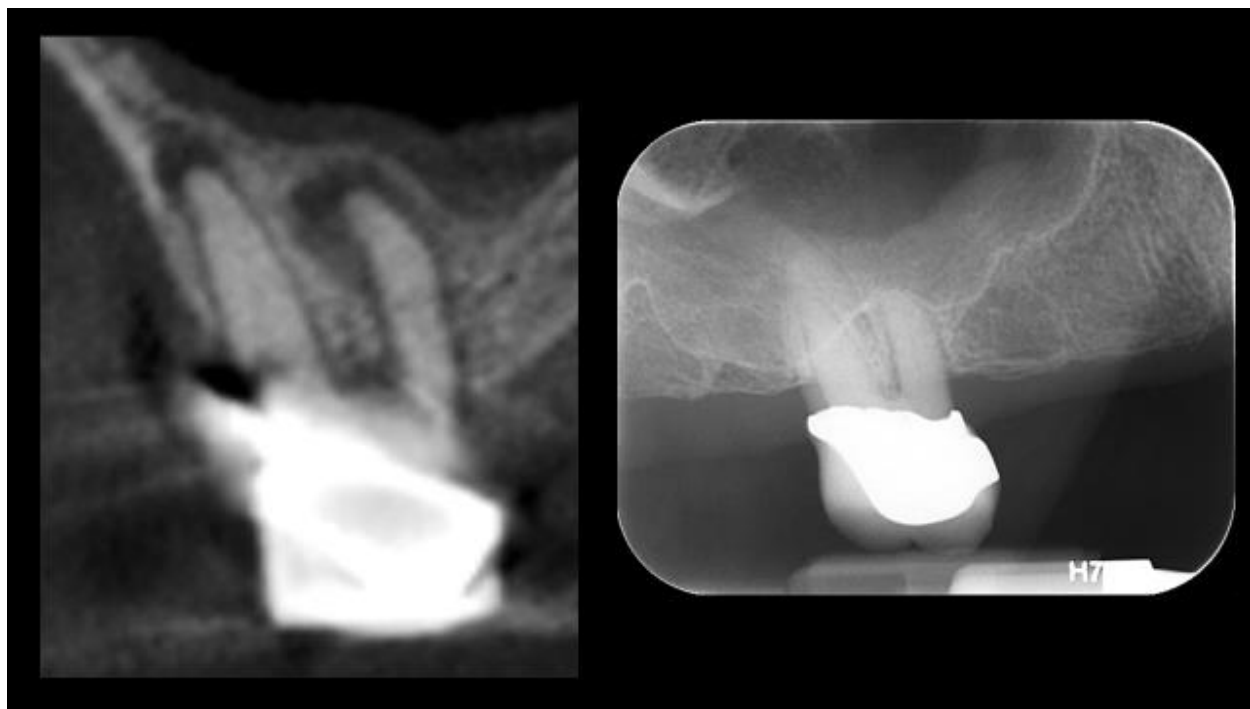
Apical lesion #3 CBCT (left) not visible on PA (right)
